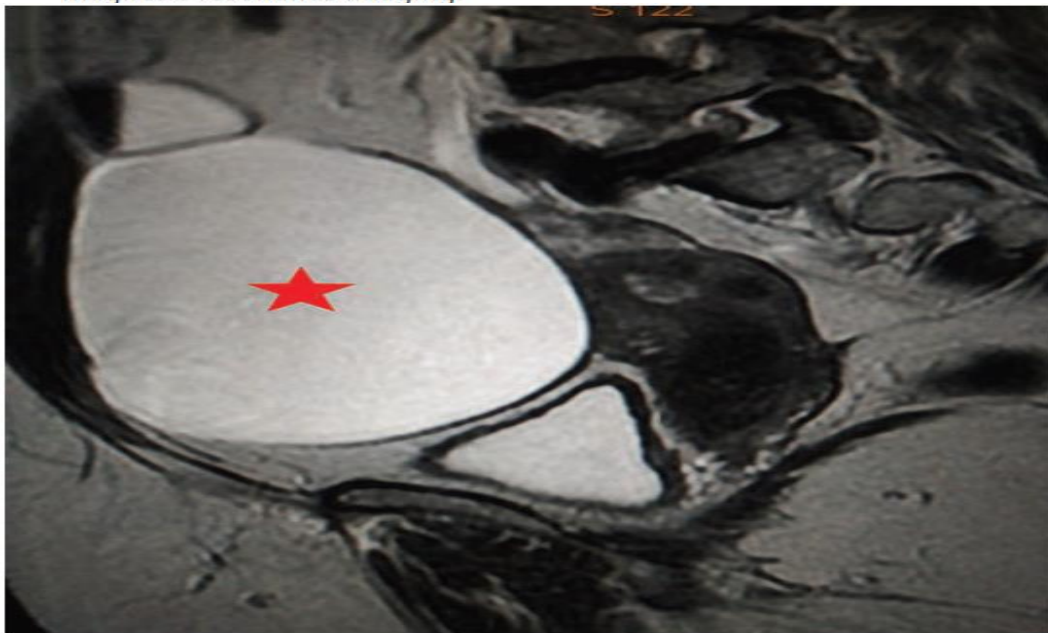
Sagittal T2-W MRI demonstrating a large well-defined thin-walled cystic abdomino pelvic lesion (star) with no solid component. MRI, magnetic resonance imaging.
